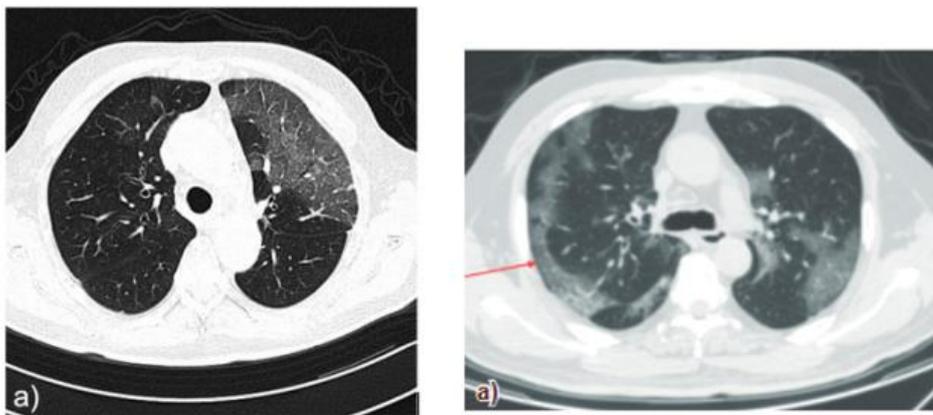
CT scans produced by different vendors can differ in quality. CT scan on the left Siemens on COVID-19 and the right CT scan from a recent publication Device made by Shimadzu Corporation.
